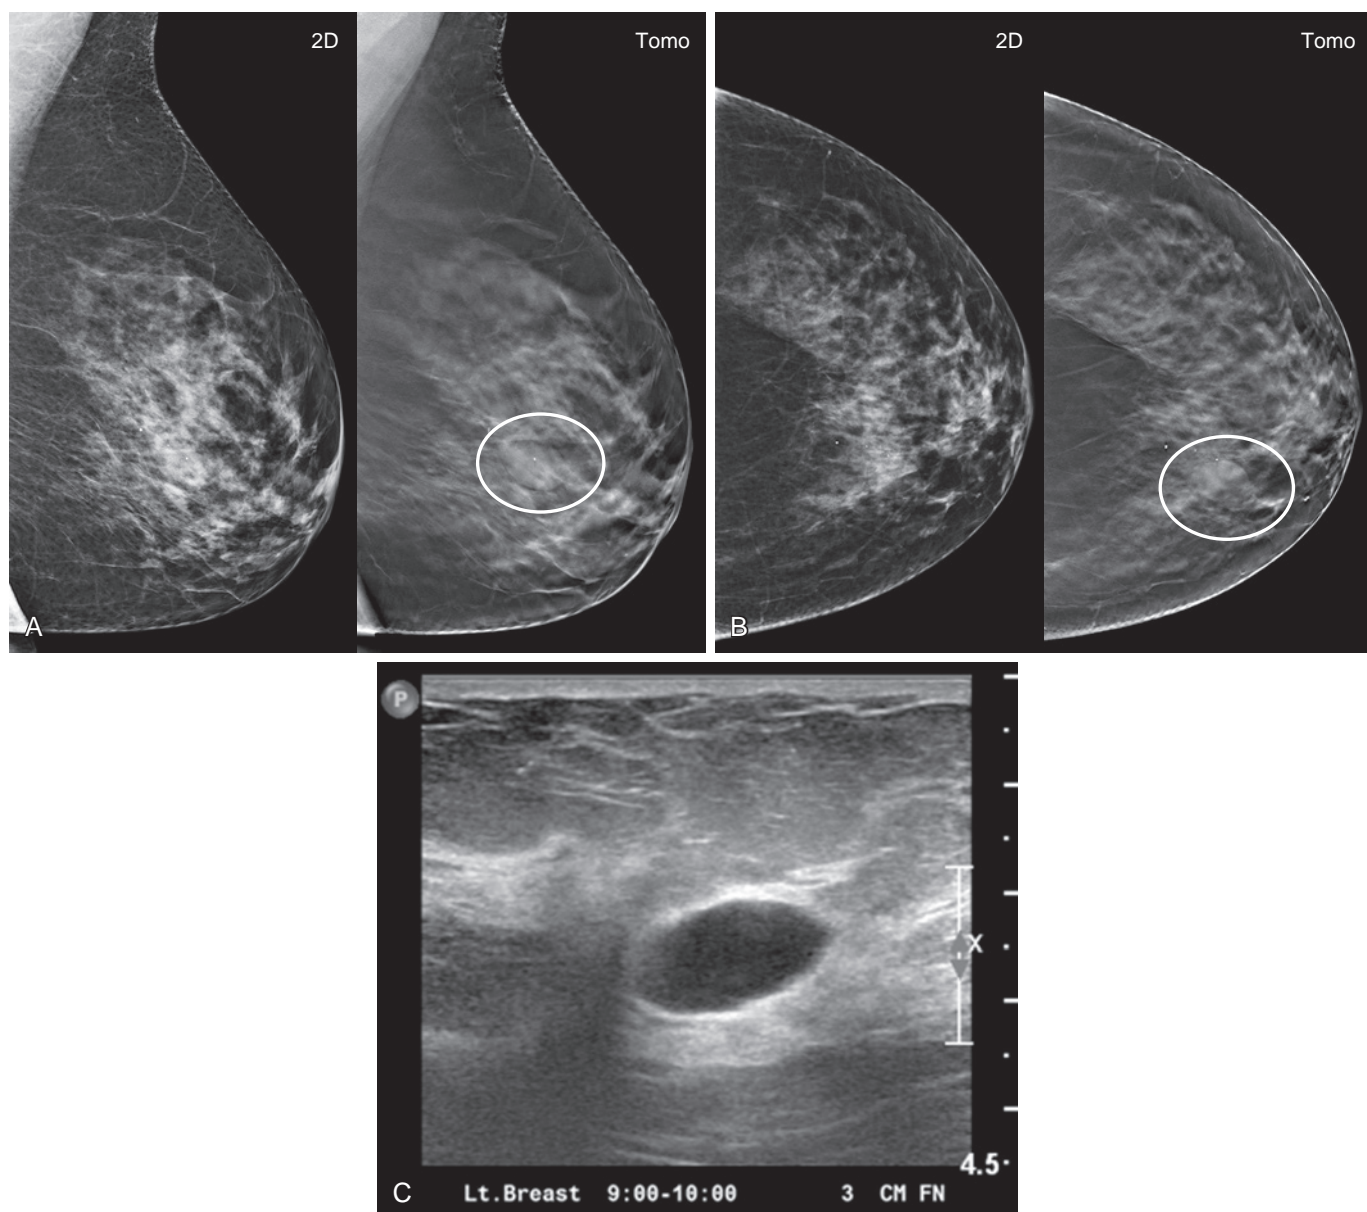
Benign cyst. A 47-year-old woman was recalled for a mass in her left breast on her first tomosynthesis screening mammogram. Prior 2D-only mammograms had been negative. (A) Mediolateral oblique and (B) craniocaudal views in 2D mammogram and tomosynthesis show an oval, circumscribed mass (*ovals*) in the medial left breast best seen on the tomosynthesis images. (C) Targeted ultrasound demonstrates a simple cyst at the 9-o'clock position, corresponding to the mass on mammography. BI-RADS 2 (return to routine screening mammography) was recommended.
